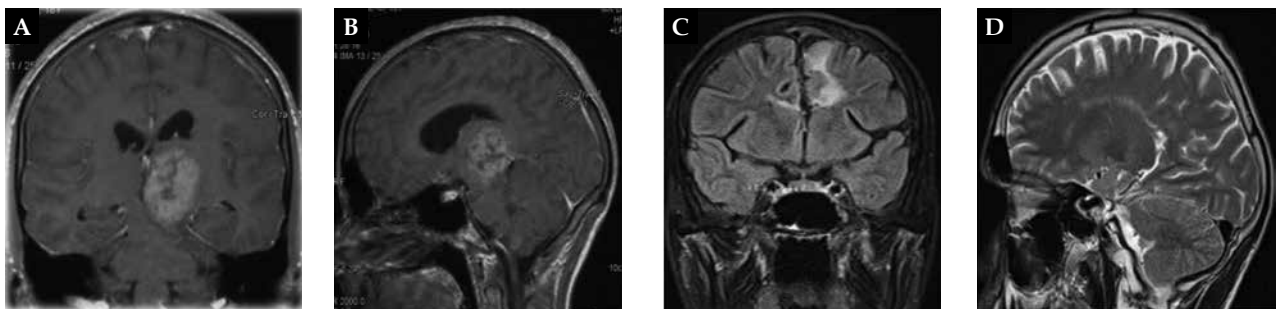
Preoperative MRI of Patient 1 shows tumour in the left thalamus; C, D. MRI of Patient 1, six years after radiotherapy and two years of GH replacement, shows no signs of tumour recurrence
